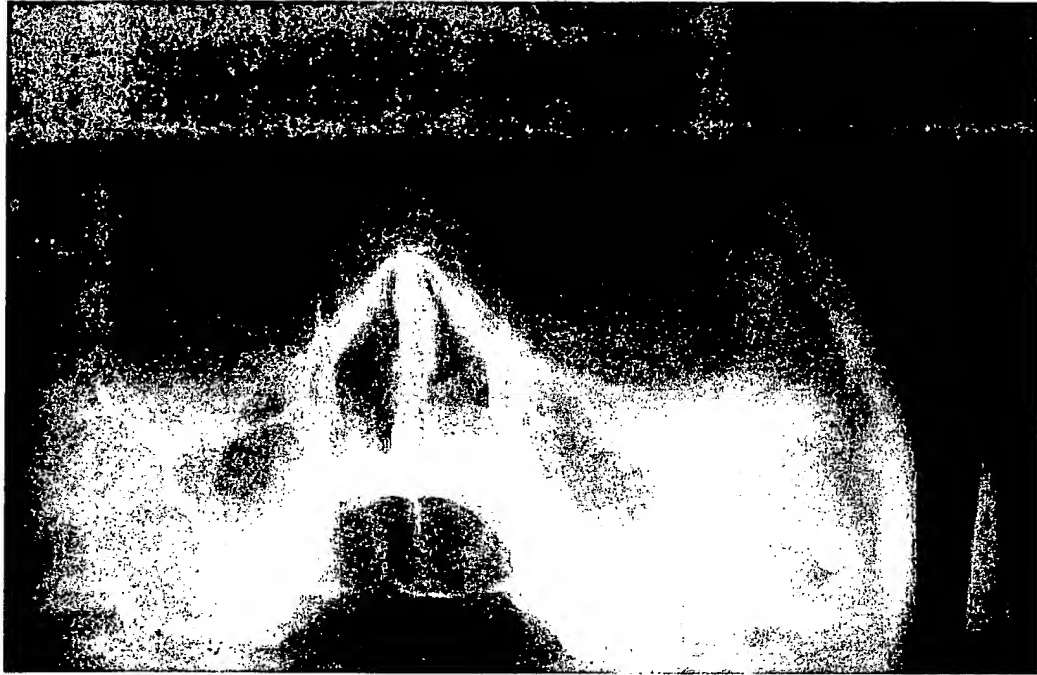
Photographs of X-ray Paranasal sinuses (PNS) of a 37 years old female patient, with chronic allergic rhinosinusitis and asthma. Figure 3: X-ray PNS shows veiling and thickening of the mucosal lining of the both maxillary antrum and bilateral hypertrophy of nasal turbinates, patient treated by conventional therapy.
